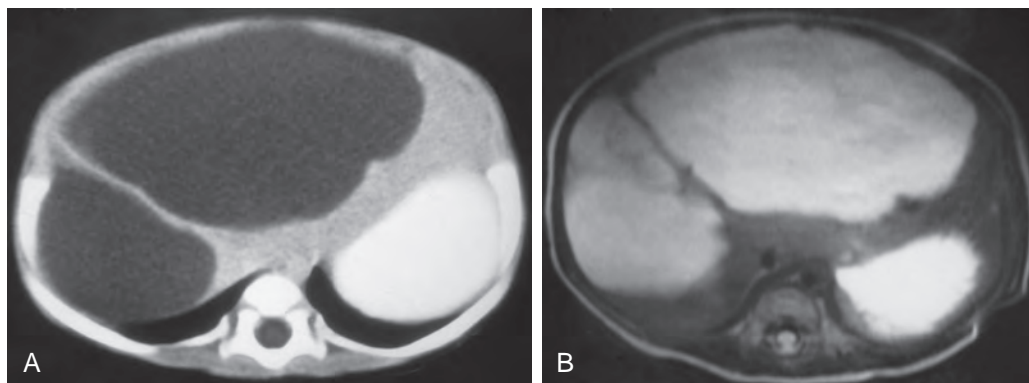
Mesenchymal hamartoma. A. Contrast-enhanced axial CT through the upper abdomen in an infant demonstrates a large cystic liver mass occupying both lobes. Notice the enhancement of the single septation. B. Axial T1-weighted MRI demonstrates the same lesion, which is almost entirely cystic.
